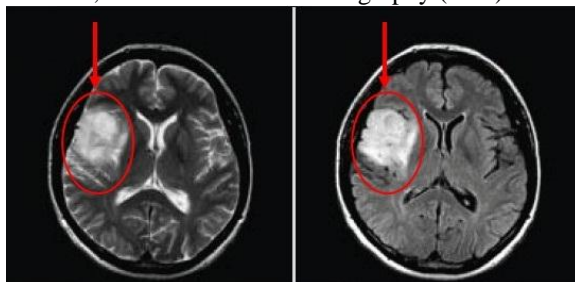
MRI scan of Brain tumour[18]
